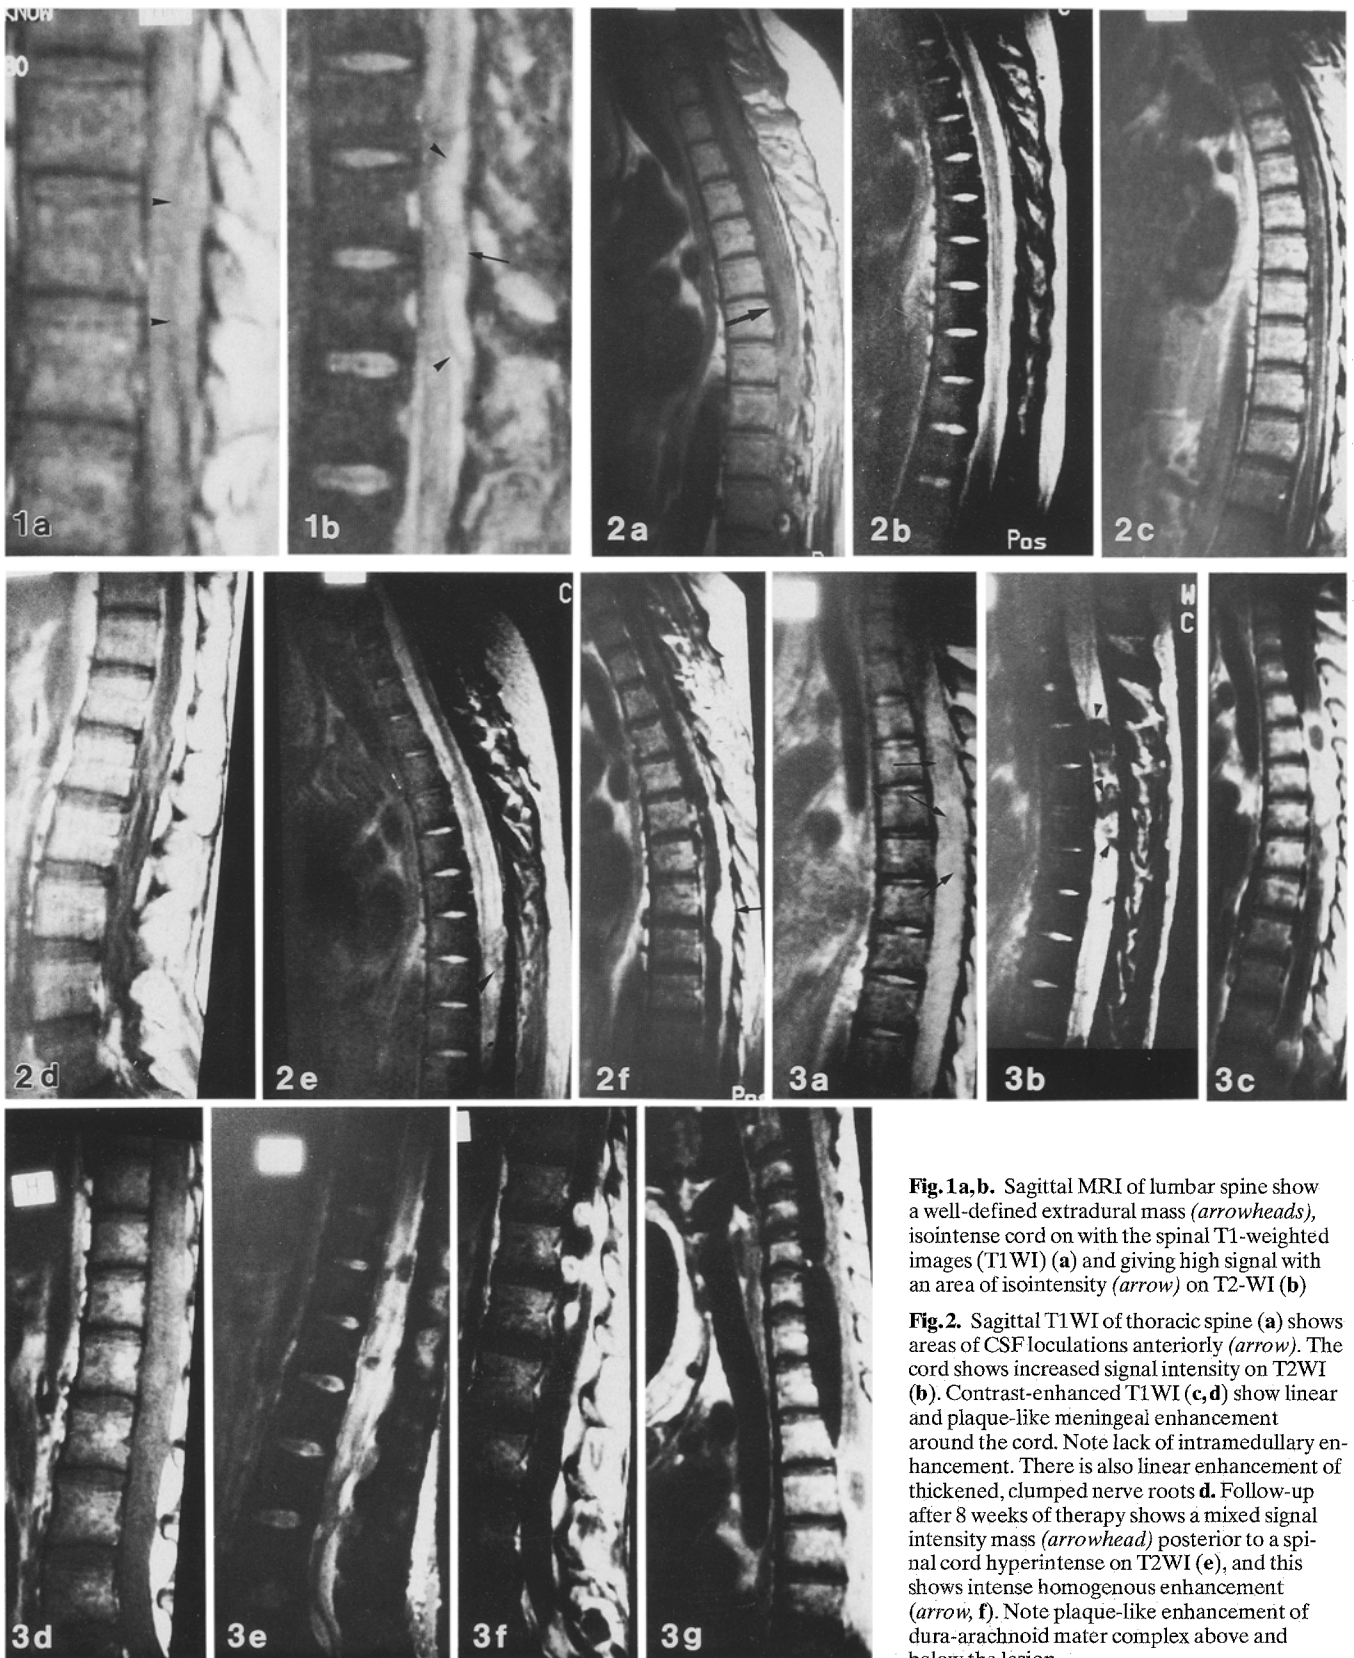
Sagittal MRI of lumbar spine show a well-defined extradural mass (*arrowheads*), isointense cord on with the spinal T1-weighted images (T1WI) (a) and giving high signal with an area of isointensity (*arrow*) on T2-WI (b)
